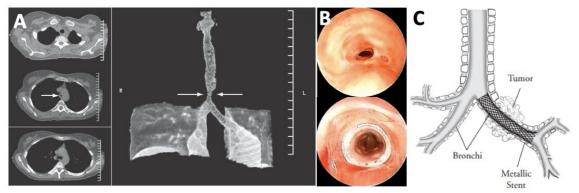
Treatment of tracheal stenosis with airway stent. A, MRI of an airway system with severe stenosis[19]. B, Example of endoscopic images of pre and post tracheal angioplasty with silicone stent[20]. C, Scheme of the treatment with a self-expanded stent to a tracheal tumor.
